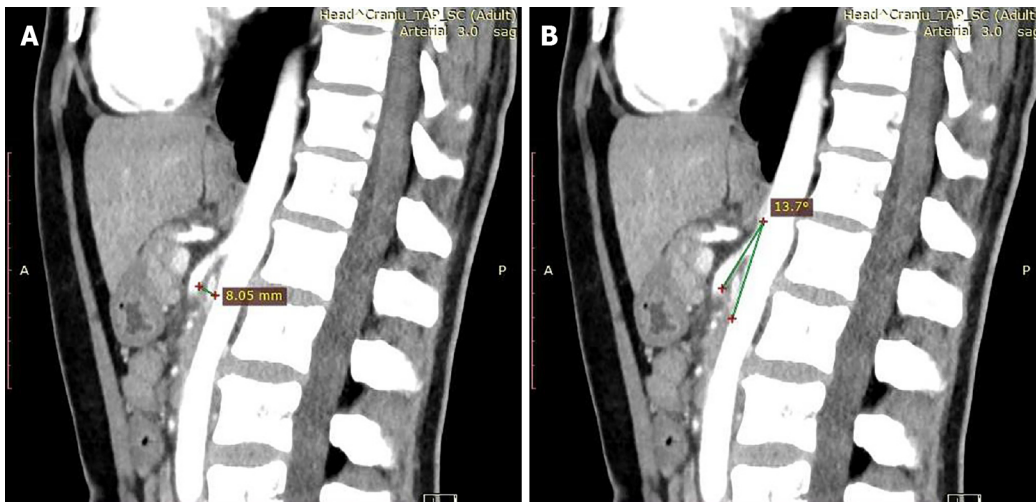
Angio-computed tomography images. A: Reduced distance between the superior mesenteric artery (SMA) and the anterior wall of the aorta up to a maximum of 8.05 mm; B: Emergence at a sharp angle of 13.7° of the SMA.
